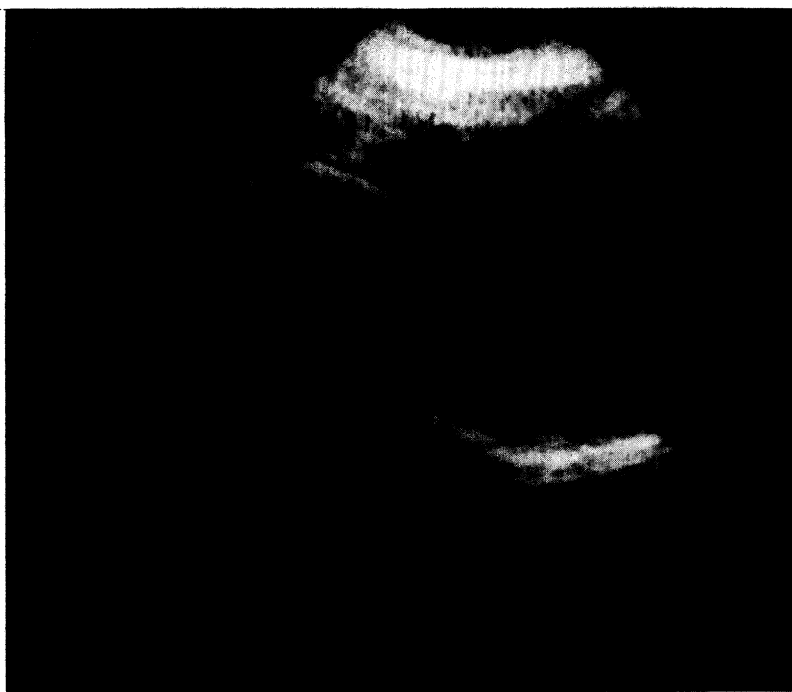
Asymptomatic 72-year-old man with the incidental finding of left upper quadrant ring calcification on an abdominal radiograph and a previous history of malignancy. A. Coronal real-time sonogram showed intrasplenic arcuate calcification (*arrow*) with posterior shadowing, obscuring the internal structure of cyst. S, spleen. B. A CT scan of the abdomen revealed an intrasplenic cyst with a thick calcified rim.
